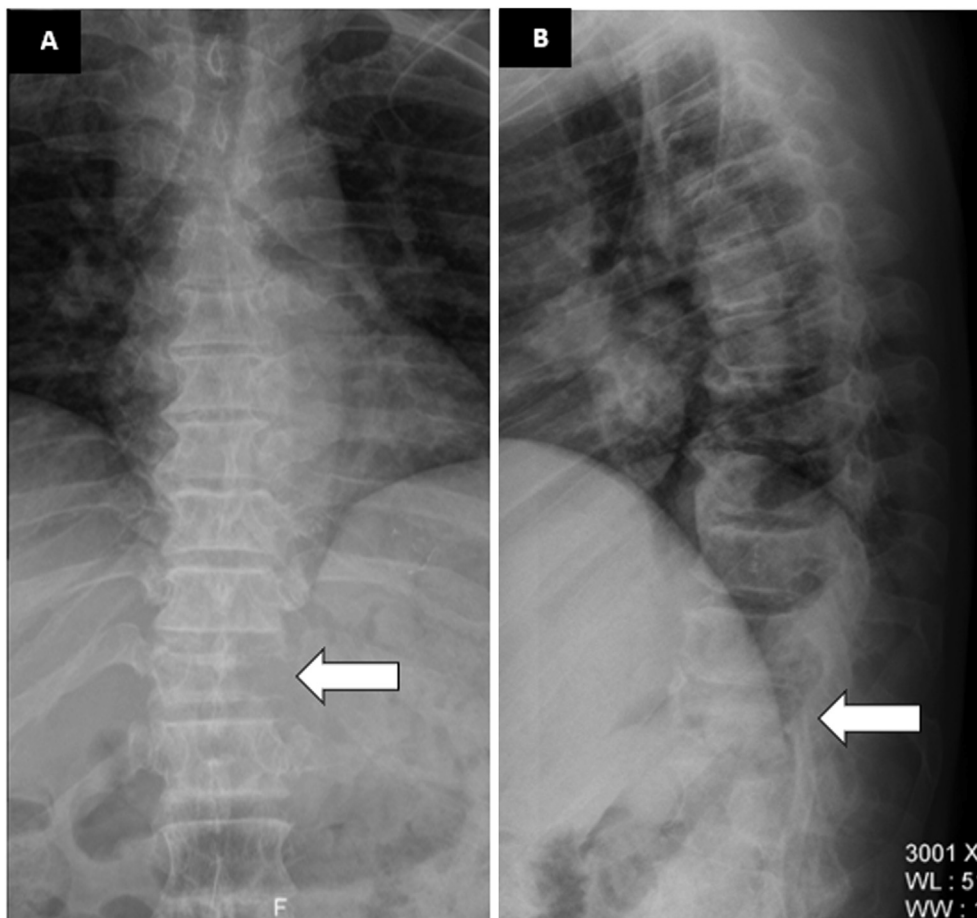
A. Frontal radiograph showing destruction of the left pedicle of the D11 vertebra (Winking Owl sign). B. Lateral radiograph showing collapse of the body of D11 vertebra (Arrow).
